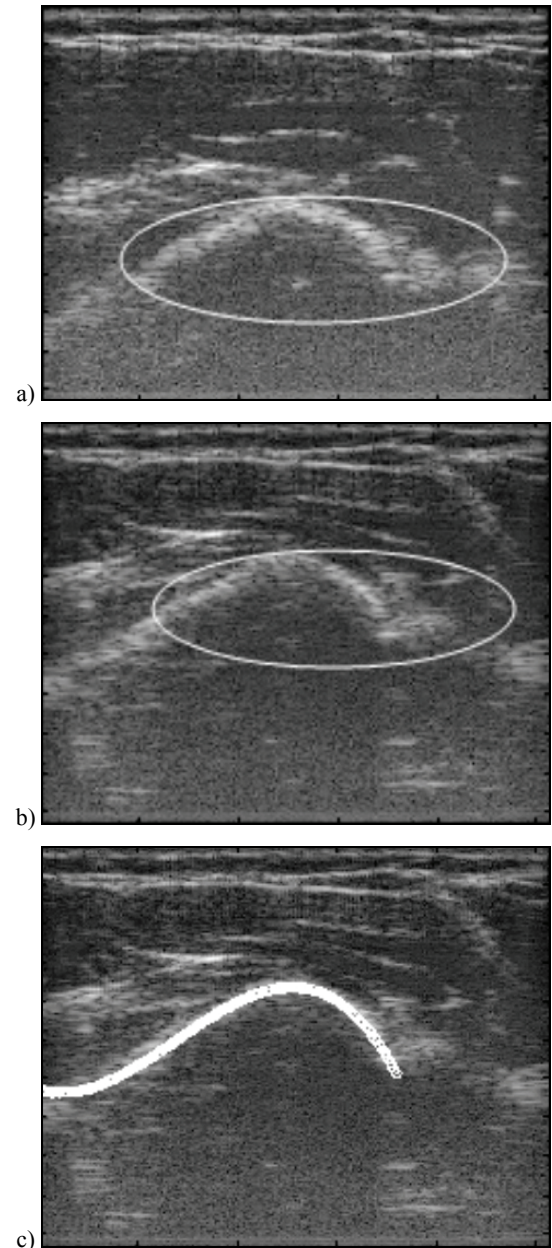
Ultrasound image without pressure (a), ultrasound image with pressure (b), bone segmentation (c). The line indicates the bone surface
